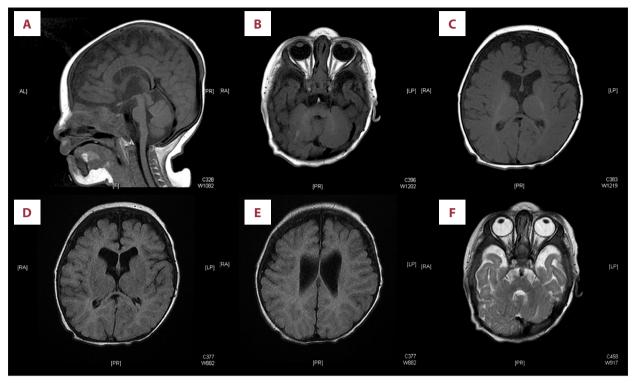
(A–F) Magnetic resonance imaging of the brain showing thin corpus callosum, bilateral widened cerebrospinal fluid spaces without hydrocephalus and age appropriate myelination. Posterior fossa structures appear normal with no gross structural abnormality.
